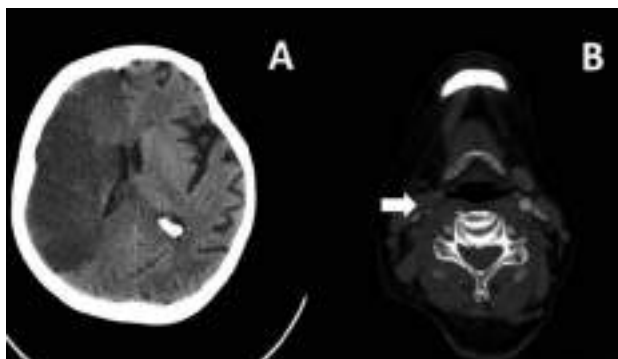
1B. Brain CT scan showing infarction in the right middle cerebral artery territory (1A); CT angiography showing right common carotid artery occlusion (1B)
